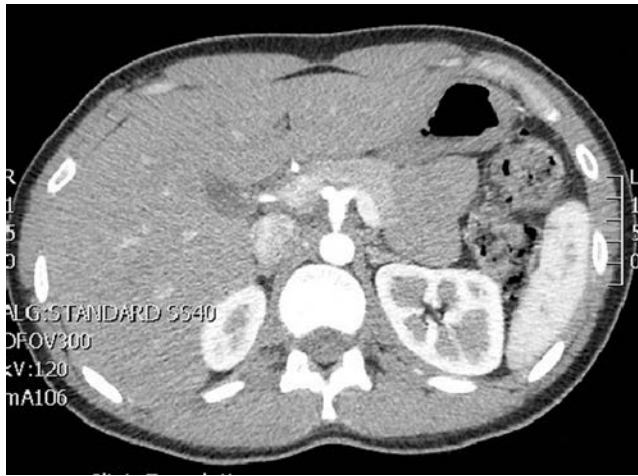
Computed tomography angiography showing stenosis of the celiac artery without any evidence of atherosclerosis. (Republished with permission of Lainez RA, Richardson WS. *Ochsner J.* 2013;13(4):561–4.²³)
